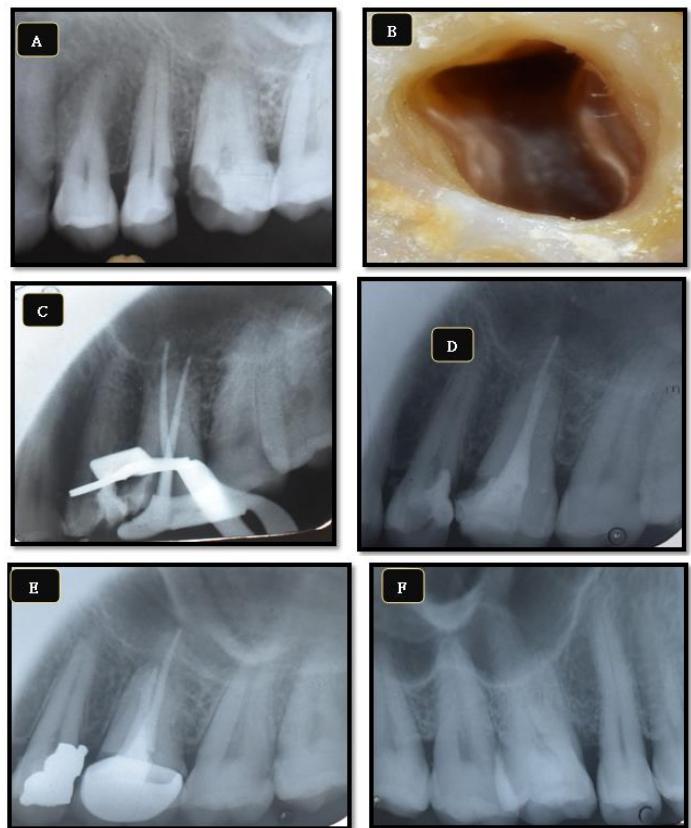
Figure A) Preoperative radiograph of two-rooted maxillary molar; B) Access cavity reveals one buccal and one palatal canal; C) The master apical cones confirmed the measured lengths; D) Final radiograph; E) 10-month follow-up; F) Intraoral periapical radiograph with 16 months confirming no bilateral occurrence of two roots with maxillary molar.
